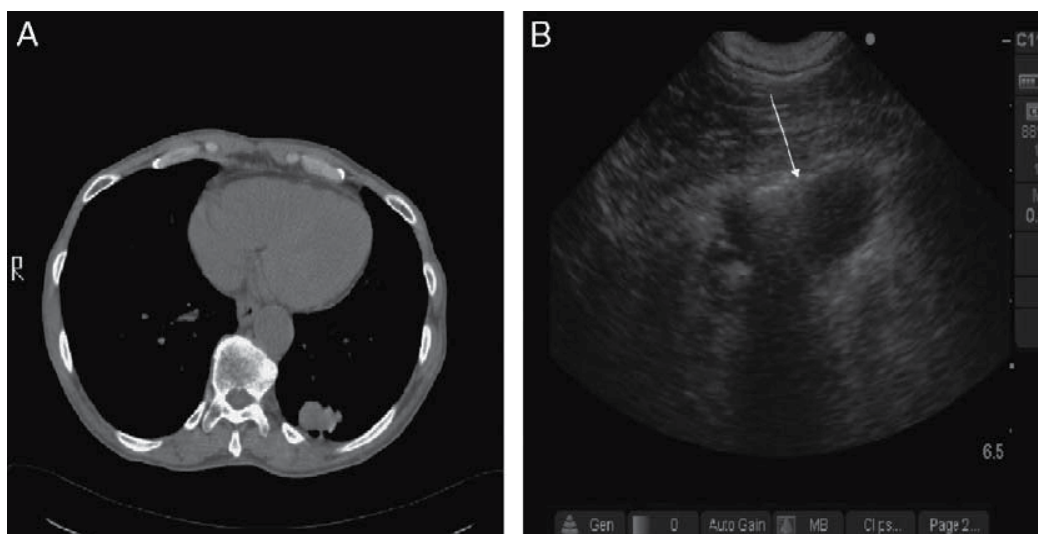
(A) Transverse computed tomography scan of the chest in a 70-year-old male smoker with weight loss reveals 2.5 x 3 cm pleural-based left lower lobe mass. (B) Ultrasound examination of the mass shows a hypodense mass not invading the pleura (white arrow)
